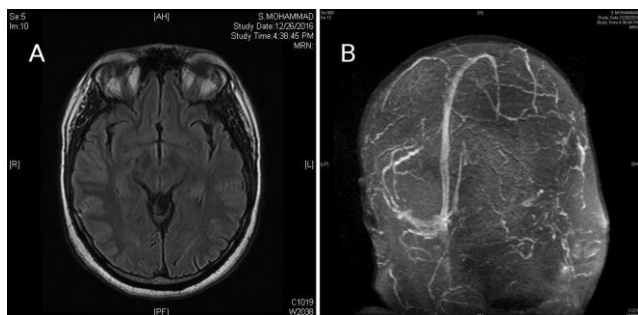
A) Normal MRI brain Axial FLAIR; B) MRV showing absent flow in the right transverse, sigmoid, and right internal jugular vein suggestive of cerebral venous thrombosis
